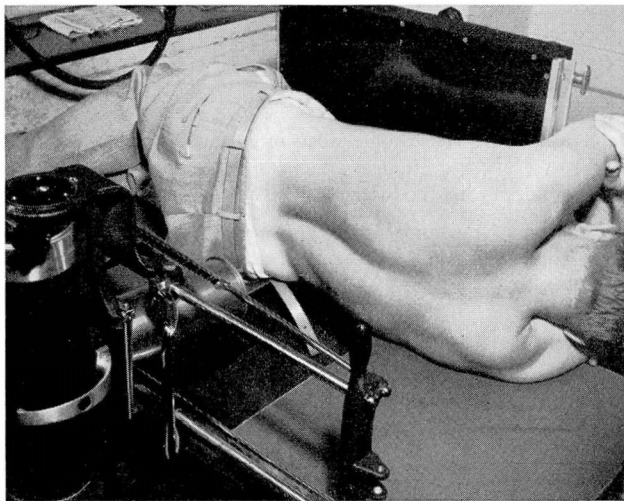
Table used for lateral decubitus roentgenograms of the gallbladder. Note the well in table top which offers no obstruction to x-ray beam and which permits the patient's right flank to drop down slightly decreasing his anteroposterior diameter.
